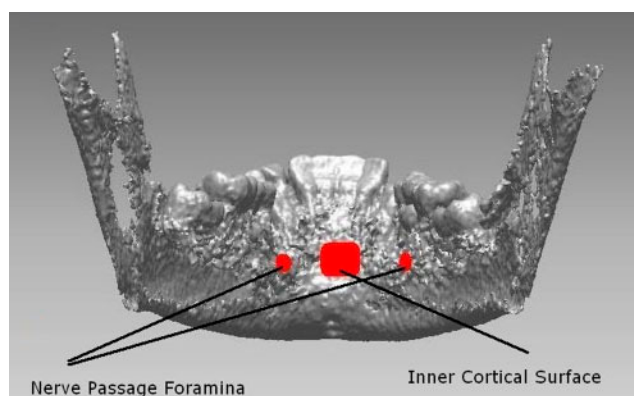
Three anatomical mandible landmarks used for multi-temporal registration of cone beam CT data, from T1 to T2. These landmarks are easily identifiable through X-ray images and are relatively stable through time
